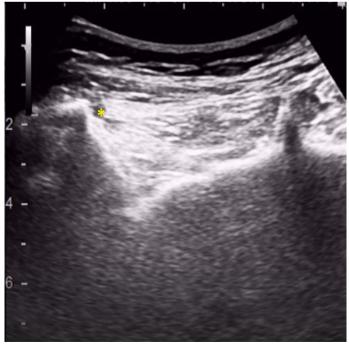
Ultrasound image of sacroiliac injection of case 2, yellow star shows the tip of the needle.
